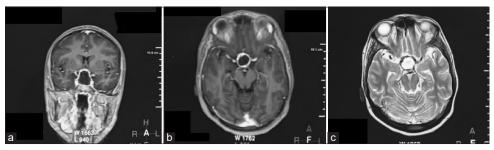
Pre-operative MRI. (a) coronal T1 with contrast, (b) axial T1 with contrast, (c) T2 sequence. MRI confirmed a $2.1 \times 2.5 \times 2.8$ cm cystic mass in the sellar/suprasellar region with thick peripheral wall enhancement without visualization of normal pituitary. The lesion's maximum thickness was 4 mm anteriorly. T2 signals demonstrate hyperintensity.
